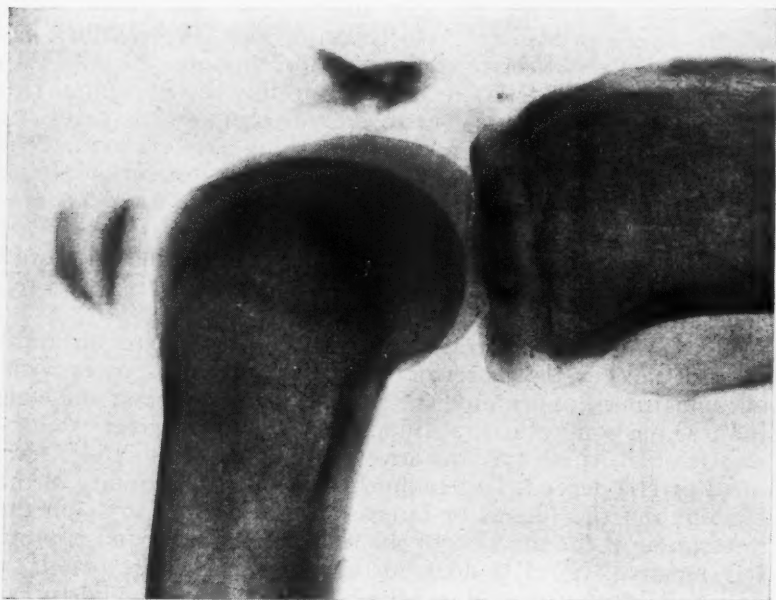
Roentgenogram showing comminution of lower third of patella following an automobile accident.
